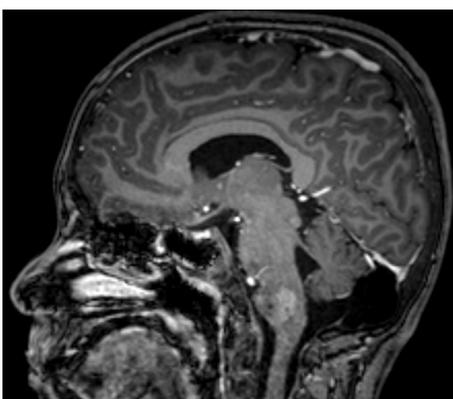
Axial and sagittal MR images of a patient with DIPG (Part 2).
